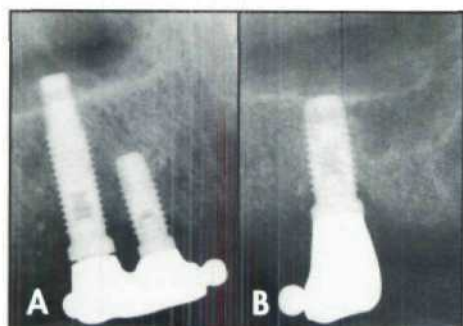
Radiograph of right maxilla 5.5 years following implant placement. 19B. Periapical radiograph of left maxilla 5.5 years postimplantation.
